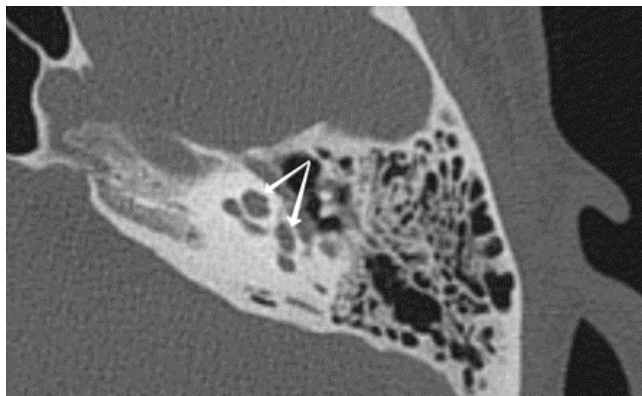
CT scan performed during the short-term postoperative period, left temporal bone of patient K. aged 32: the arrows indicate the cochlea and vestibule filled with liquid content
